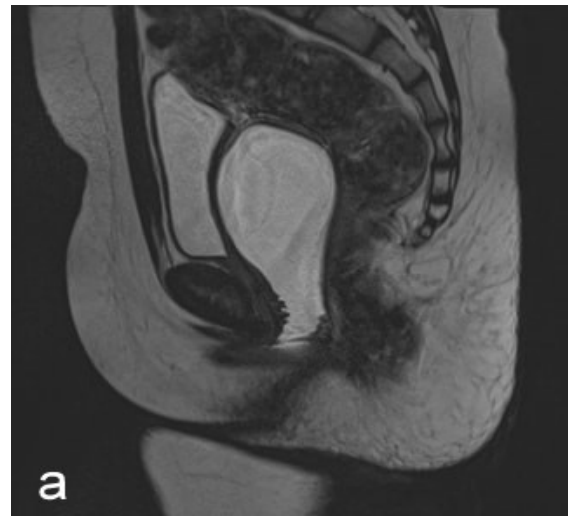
T2W MRI of pelvis sagittal view: (a) Fluid filled vagina - hydrocolpos when urinary bladder is full, (b) Complete resolution of hydrocolpos after voiding.
